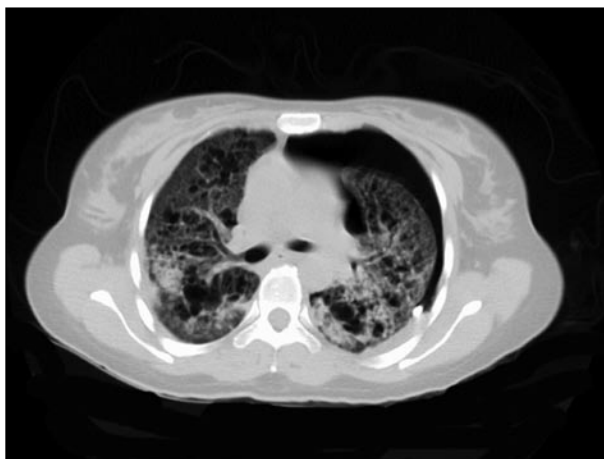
Follow-up CT scan of the chest showing left pneumothorax and bilateral cystic lesions of varying sizes
